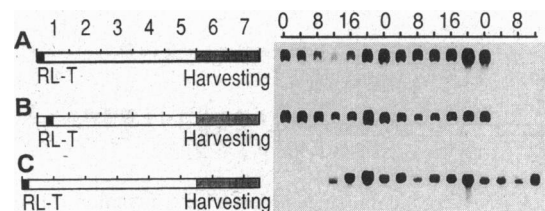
Sowing and/or germination induces rhythmic Cab mRNA accumulation in a red-light-independent fashion. Seeds were sown at 0800 (A and B) or at 2000 (C). Seeds were treated with red light for 3 h after sowing (A and C) or were germinated for 9 h in dark, treated with red light for 3 h, and returned to constant darkness (B). RL-T, red light treatment. (Left) The numbers 1–7 indicate days after sowing. (Right) Numbers show the CT (as in Fig. 1) on the days of harvesting. Harvesting started at CT0 (A and B) or at CT12 (C). Each lane contains 20 μ g of total RNA. Each filter was uniformly exposed for 48 h.
